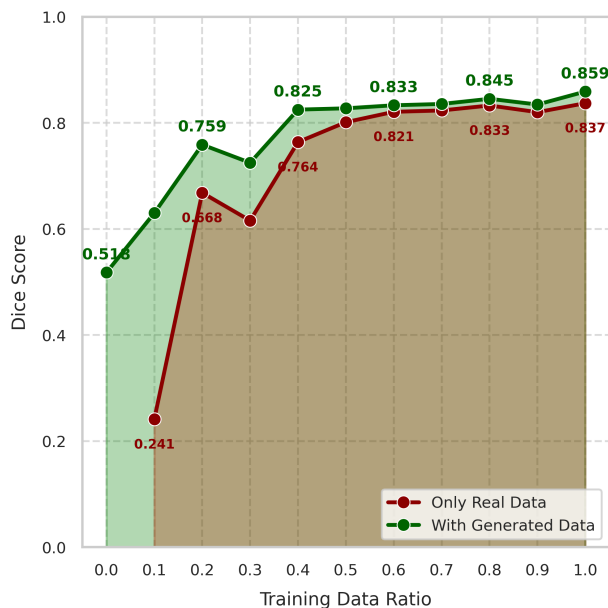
Dice similarity scores across varying real training data ratio (ratio of how much of the real dataset was used, zero meaning non real slices and 1.0 meaning all of the real slices from MRI volumes were used), showing consistent improvements when augmenting with synthetic data, particularly in low-resource scenarios
